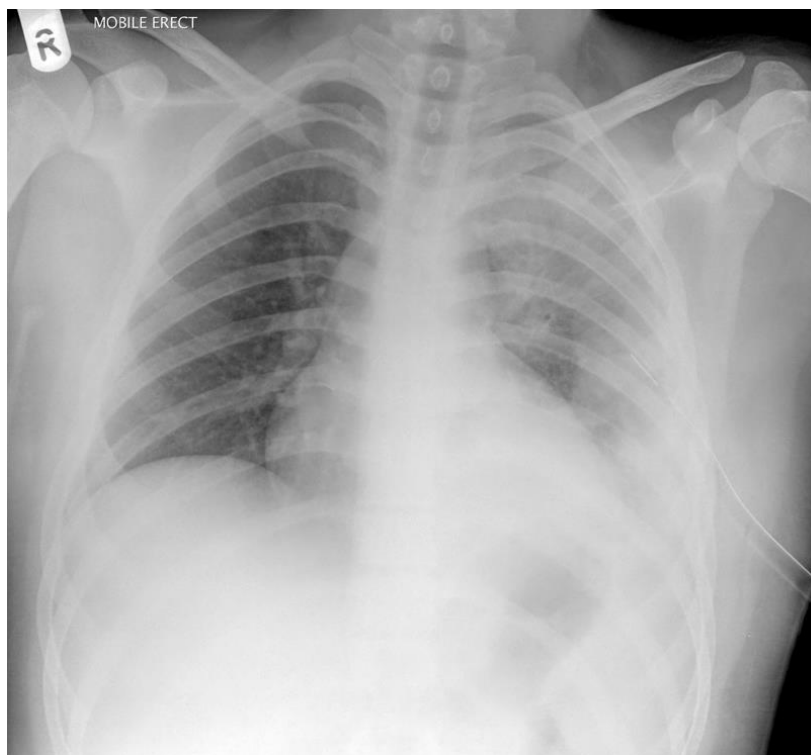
Plain radiograph showing pleural empyema in a teenager. Note the obliteration of the cardiophrenic and costophrenic angles in the left hemithorax. A chest drain has been placed for pleural drainage.
